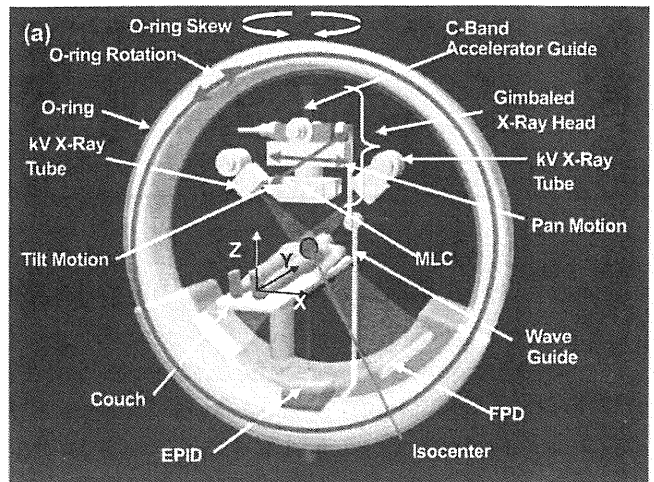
(a) The gimballed X-ray head is mounted on the O-ring with two kV X-ray tubes, two flat panel detectors (FPDs), and an electronic portal imaging device (EPID). The O-ring can be rotated 360° around the isocenter and can be skewed $\pm 60^\circ$ around its vertical axis. The couch has motion in X, Y, and Z. The waveguide provides microwave energy to the X-ray head. The X-ray head has a multileaf collimator to control dose distribution. (b) The pan and tilt rotations provide a precise and quick beam motion around the isocenter.
